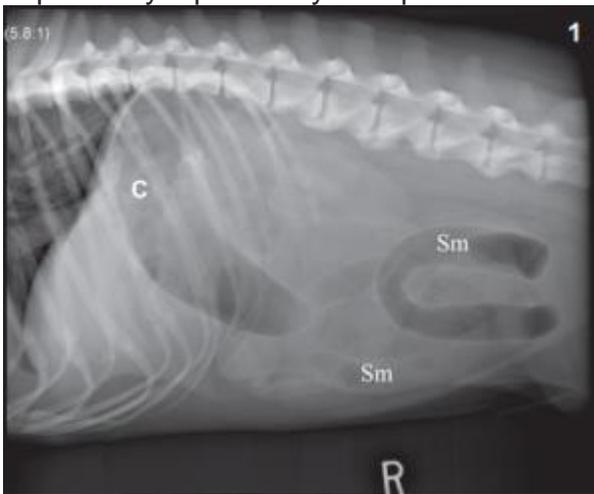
Lateral abdominal radiograph. c=abnormally distended colon; sm= diffuse dilated bowel loops.
